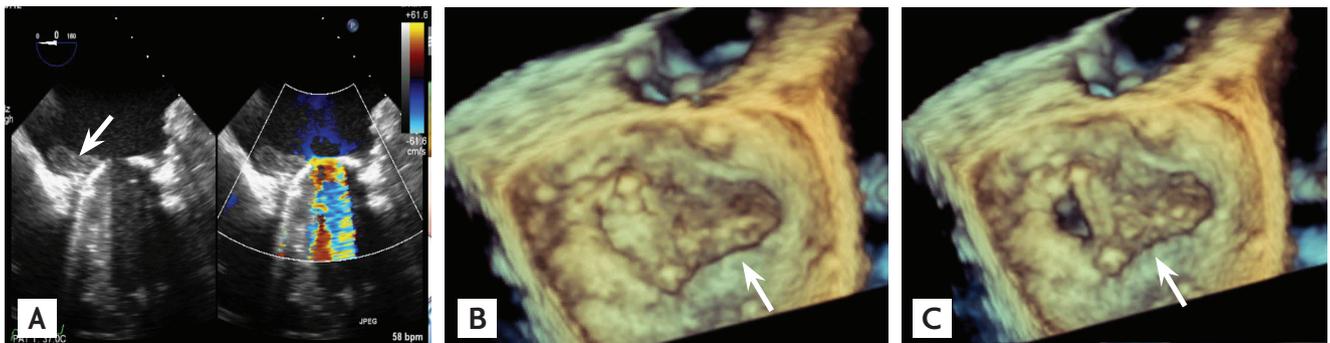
(A) Upper panel shows 2-dimensional (D) transesophageal (TEE) images without (left) and with (right) color Doppler in a patient with thrombus formation on the mechanical mitral valve (arrow). The lateral leaflet does not open. Lower panels show real-time 3D TEE images from the same patient, (B) left in systole and (C) right in diastole. A large thrombus is well visualized with 3D TEE (arrows).
